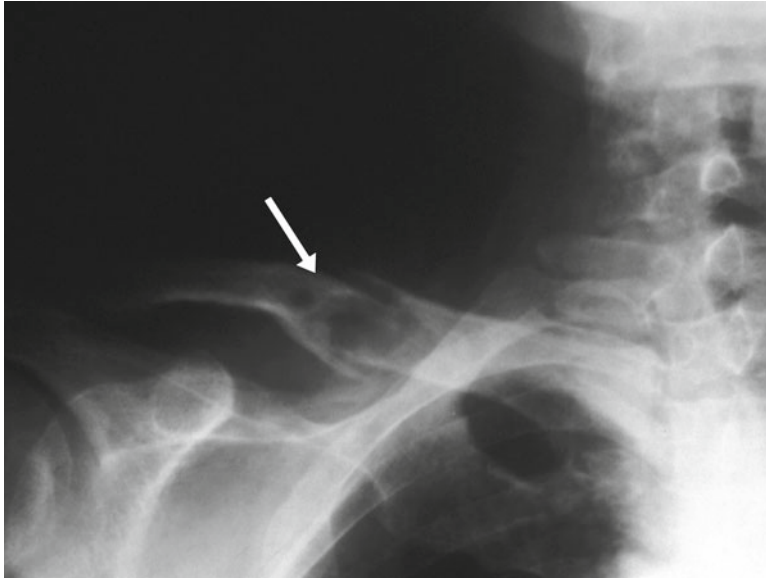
Plain radiographs of the right clavicle: presence of a pathological fracture of a lytic bone lesion (Brown's tumor)
